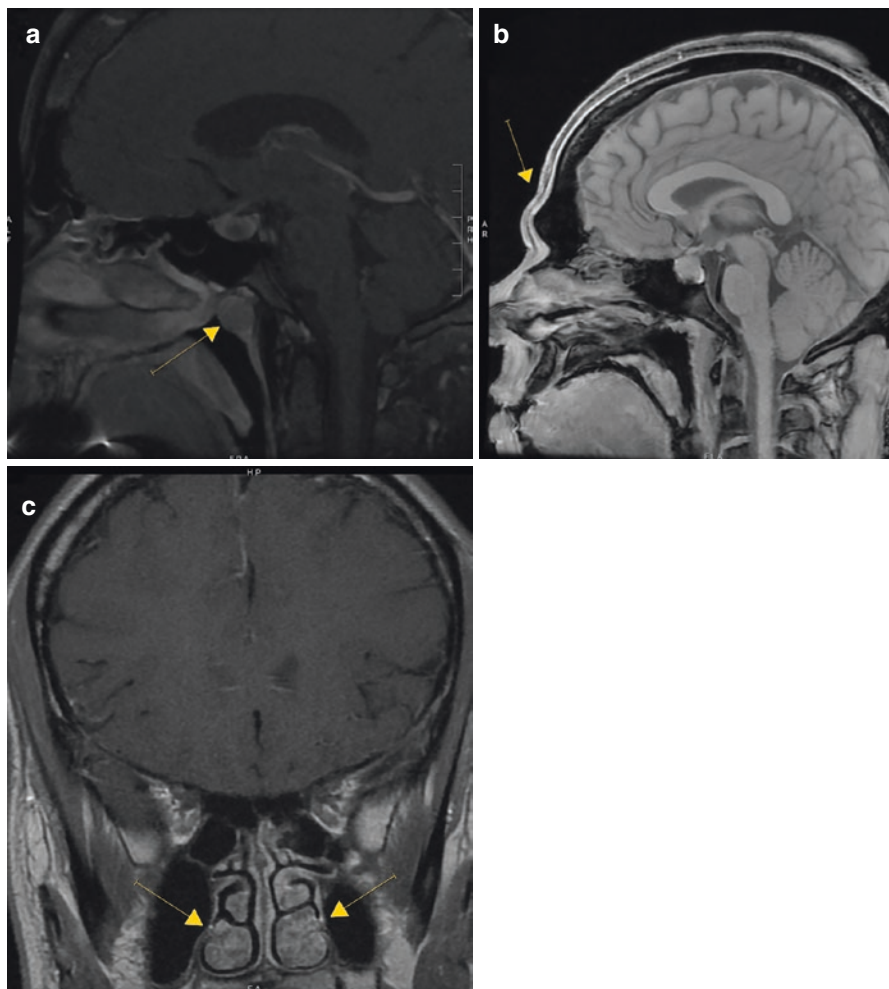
Examples of sinonasal anatomic findings in acromegalic patients. (a) 36-year-old man with acromegaly-induced nasopharyngeal adenoid enlargement due to lymphoid adenomatous hyperplasia, evident on sagittal, gadolinium-enhanced T1 MRI, and intraoperatively found to have 5–8 mm cystic deposits within the adenoids. (b) 31-year-old man with obvious acromegalic features on exam including frontal bossing (seen here on sagittal MRI), high zygomatic arches, thickened lips and nose, enlarged hands, mild thenar wasting, deepening of the voice, and substantial muscularity. (c) 23-year-old woman with significant acromegaly-induced turbinate hypertrophy evident on coronal, gadolinium-enhanced T1 MRI, and evident intraoperatively during approach to the sella
